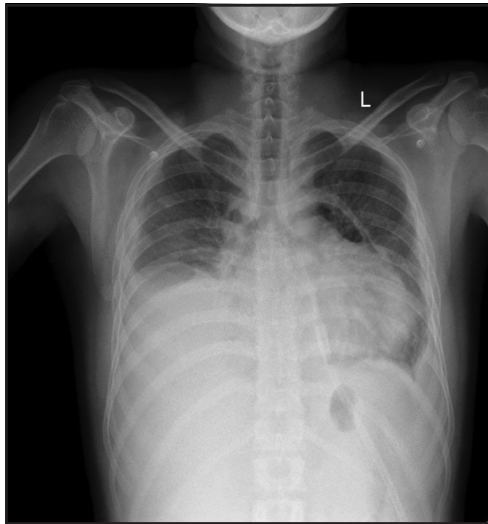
Chest X-Ray showing enlarged cardiac silhouette with bilateral pleural effusion (right more than left) and evidence of an air fluid level in the left paravertebral region in upper and middle zone.
